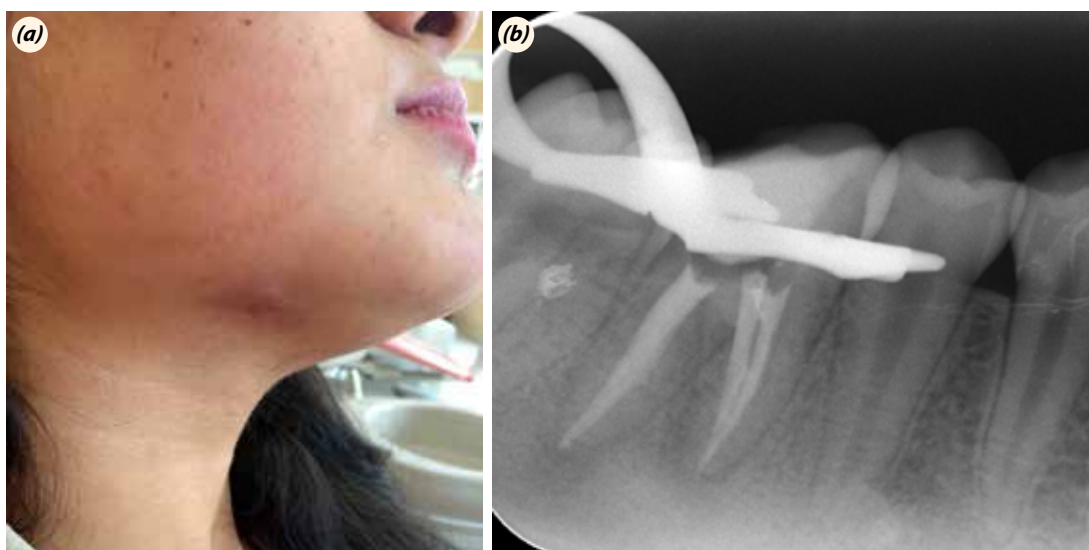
(a) Healing after 10 months. (b) Complete healing of the periapical lesion.
